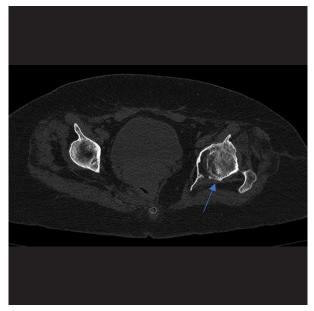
Pelvic CT scan showing the extent and characteristics of the extensive osteolytic lesion in the left iliopubic and iliac branches, with irregular edges and areas of peripheral sclerosis (blue arrows).
